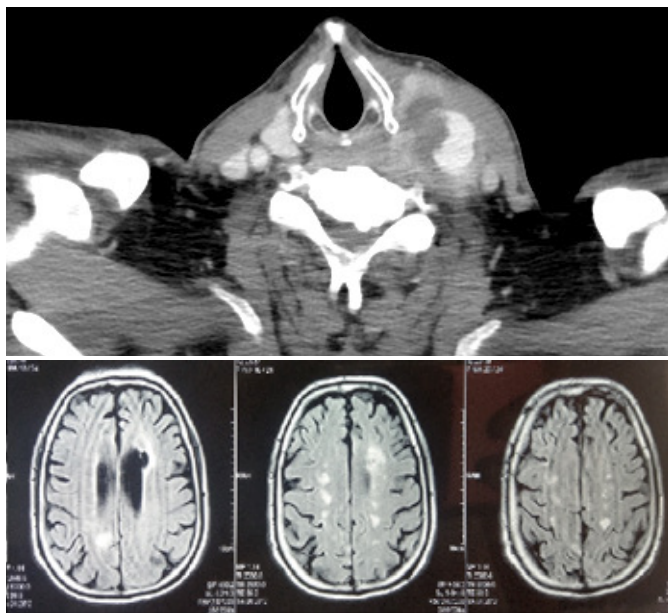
A computed tomography angiography revealing the pseudoaneurysm with the thrombus in it and magnetic resonance of the brain indicating bilateral brain infarctions.
